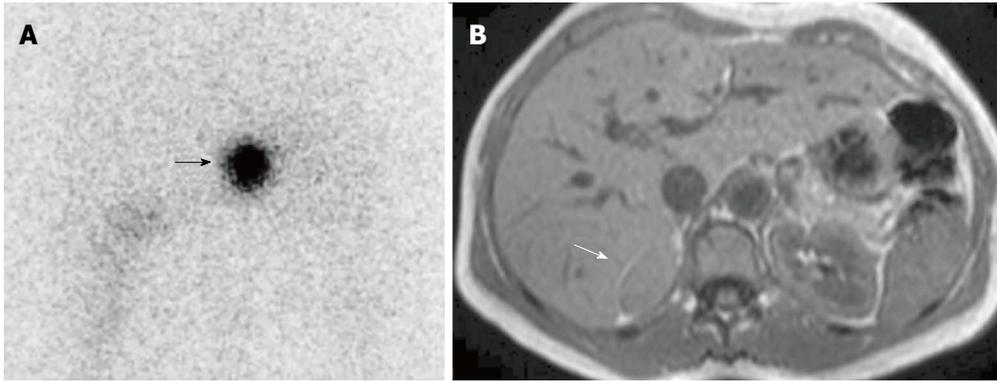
Right hypersecreting adenoma of the adrenal gland. A: Abdominal posterior scan of I-131 nor-cholesterol scintigraphy demonstrates abnormal (intense) focal uptake in the right adrenal (black arrow) where a mass was detected by magnetic resonance (MR); no uptake is detected on the contralateral side; normal bowel uptake is detectable on the left; B: T1-weighted axial MR detects a right adrenal lesion isointense compared to liver signal intensity (white arrow).
